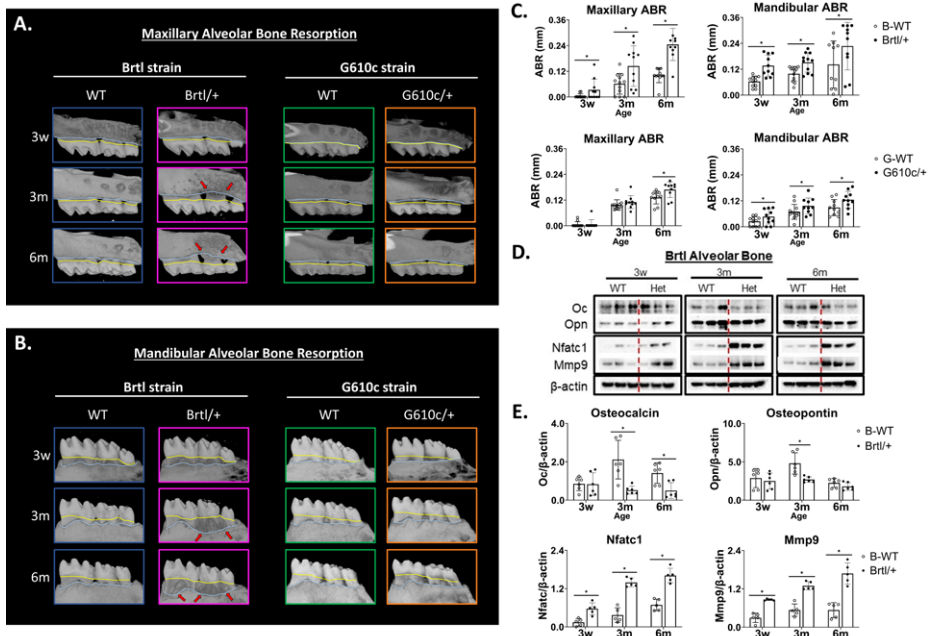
Alveolar bone resorption. (A) Sagittal μ CT images of maxillary alveolar bone showing bone resorption by genotype and age, with cyan line depicting the alveolar bone level and yellow line depicting the cemento-enamel junction; red arrows indicate severe resorption sites. (B) Sagittal μ CT images of mandibular alveolar bone showing bone resorption by genotype and age, with cyan line depicting the alveolar bone level and yellow line depicting the cemento-enamel junction; red arrows indicate severe resorption sites. (C) *Brlt* and *G610c* maxillary and mandibular alveolar bone resorption graphs, with asterisk representing P -value $\leq .05$. (D) Western blot of *Brlt* alveolar bone. (E) Western blot graphs asterisk representing P -value $\leq .05$.
